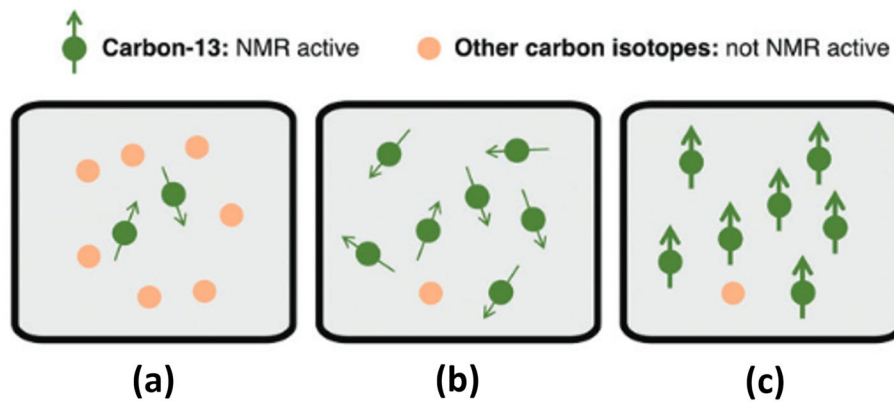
Process of Hyperpolarization. a Distribution of a very small number of carbon atoms, which are ^{13}C -labeled at equilibrium with not well-aligned spins. Based on HP principle, high levels of polarization could be transferred to ^{13}C -labeled probes, which increases their MRI signal b ^{13}C enrichment results in the increased number of ^{13}C -labeled carbon atoms. Transfer of polarization takes place as
